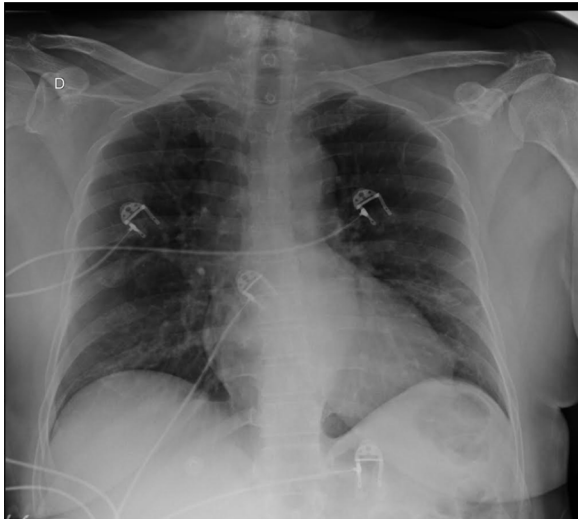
Chest X-ray with peripheral opacities in inferior lobes of both lungs.
